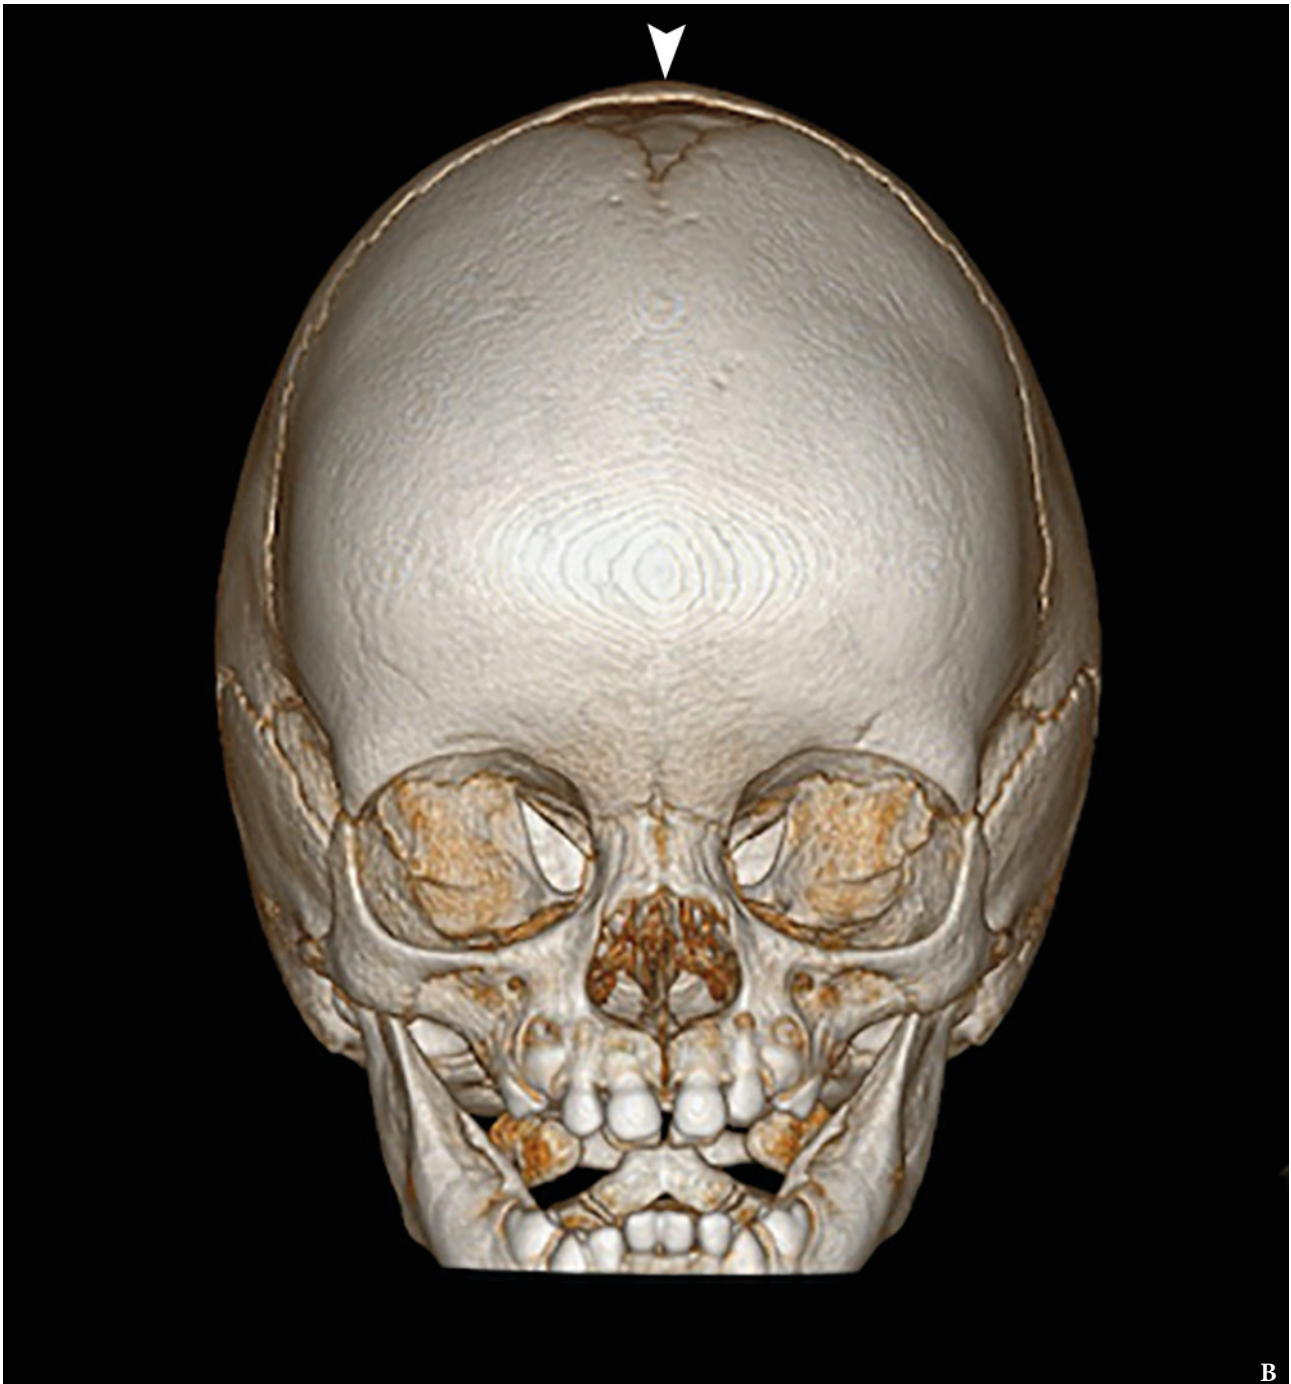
(cont'd). Anterior view (B) of 3D-CT volume-rendered image of a 6-month-old boy with premature, complete fusion of the sagittal suture. It results in increased anteroposterior diameter, along with bitemporal narrowing due to restriction of biparietal growth. Prominent ridging (*arrowhead*) of the sagittal suture is observed, as well as frontal and occipital bulging. (Fig 1 continued on next page.)
